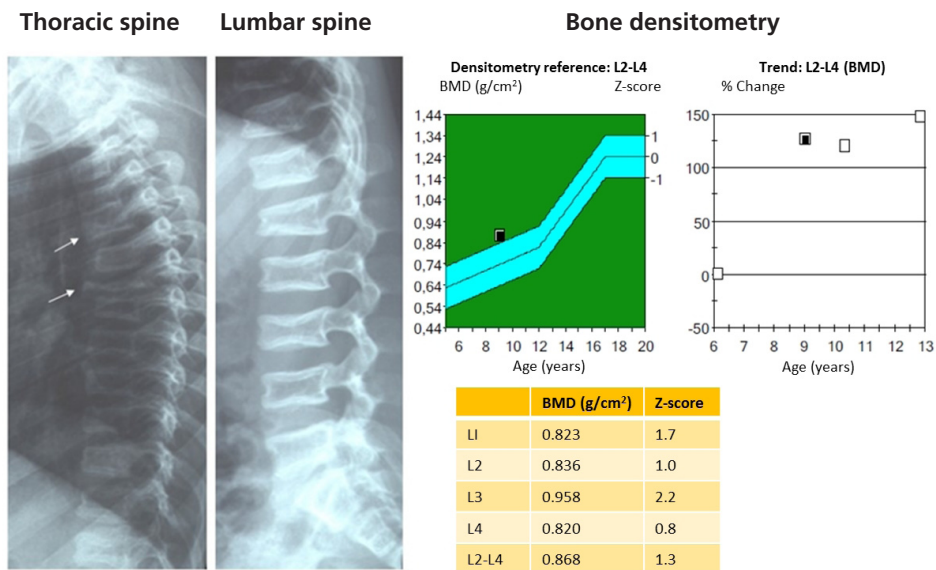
Spinal radiographs and bone densitometry in a 9-year-old boy with systemic arthritis. Multiple compressed vertebrae in the thoracic and lumbar spine were observed. Vertebrae Th 4 and 6 were totally collapsed (3b) (arrow), and grade 2b-3a fractures were observed in vertebrae Th5 and Th7-L5. Because of bisphosphonate therapy, vertebrae have sclerotic margins and are therefore more visible. Lumbar spine DXA results of the same patient show rather high BMD values, resulting from bisphosphonate therapy and compression changes in the measurement area.
